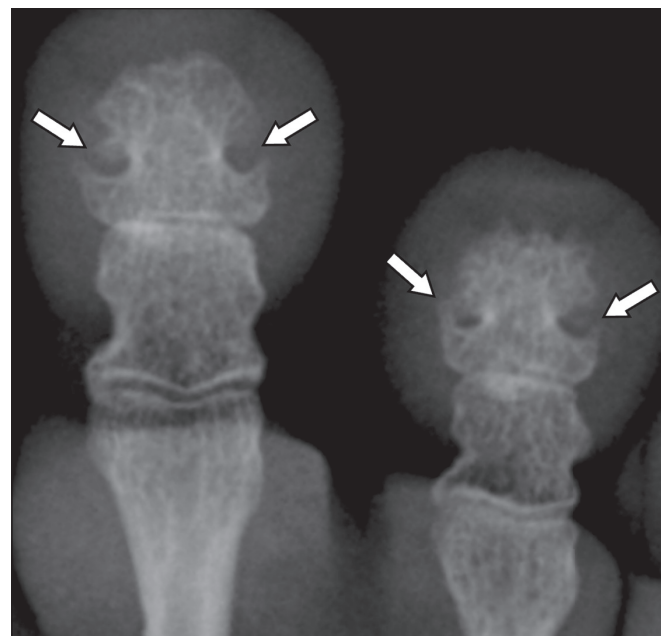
Radiograph of the distal phalanges in the foot of a patient with acromegaly, showing marked hypertrophy of the bases and terminal tufts, leading to the formation of a pseudoforamen (arrowheads).
